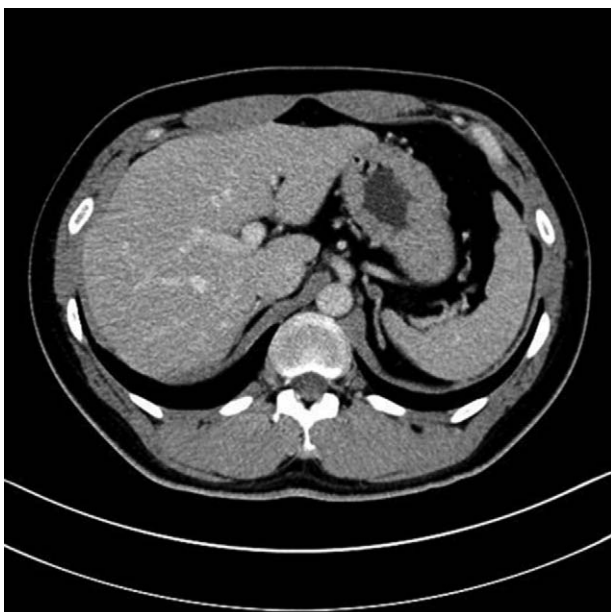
CT scan showing left adrenal gland hyperplasia and nodular protrusions. CT=computed tomography.
